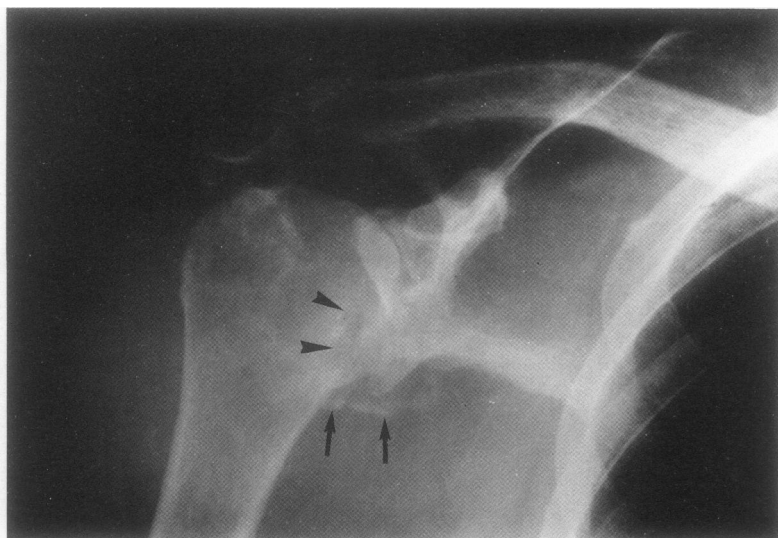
Right shoulder radiograph shows a lytic area in the humeral head (arrowheads). Joint space is preserved, with collection of bony densities inferior to the joint (arrows). There is patchy periarticular osteoporosis.
